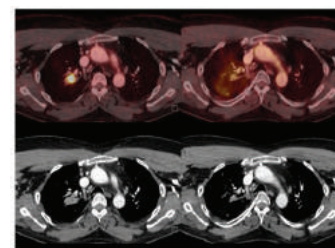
PET –CT scan at 6 months post SBRT: Images on Right – Pre –SBRT & Images on Left – Post-SBRT
